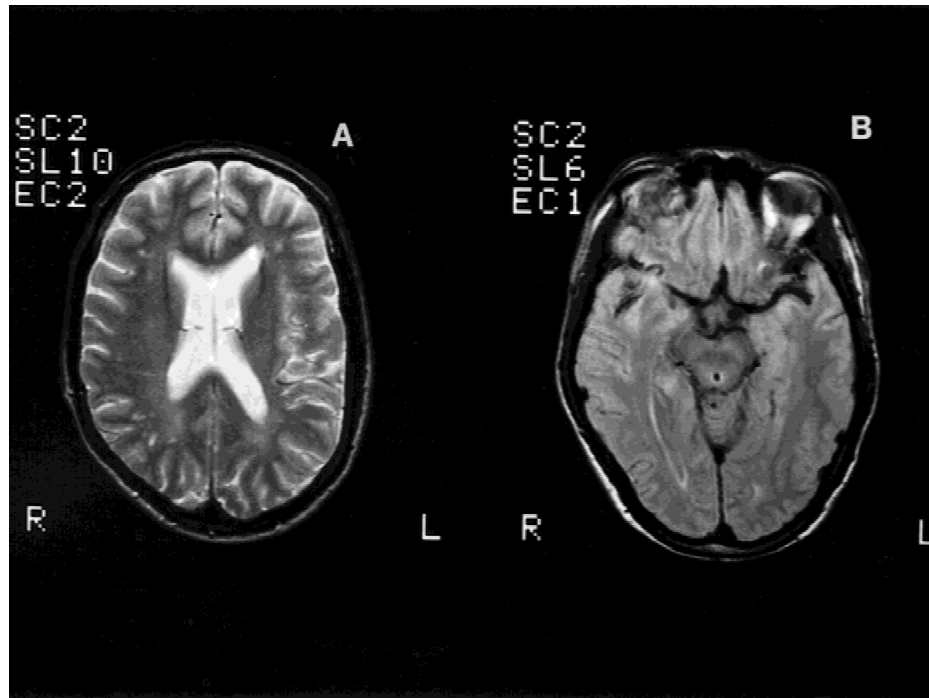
(A and B) MRI (0.5 T) axial scans (T2-weighted [SE, 7 mm thick, 0.7 mm gap, TR 2500, TE 40/100]) demonstrate skull and encephalic asymmetry and a hypoplasia of the right side. There is a mild enlargement of the ventricular system with smaller right lateral ventricle and mild cortical atrophy.
